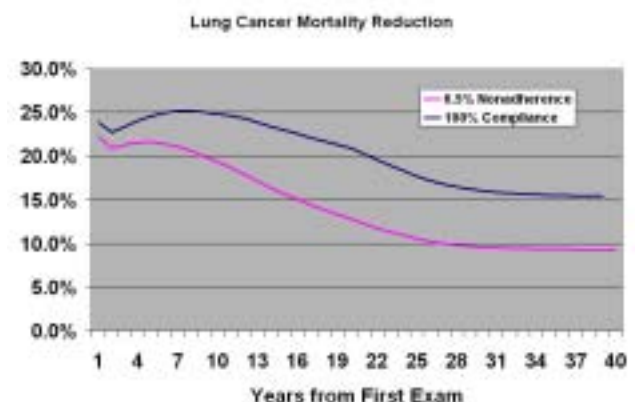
Lung Cancer Mortality Reduction due to annual CT screening for 20 years.
